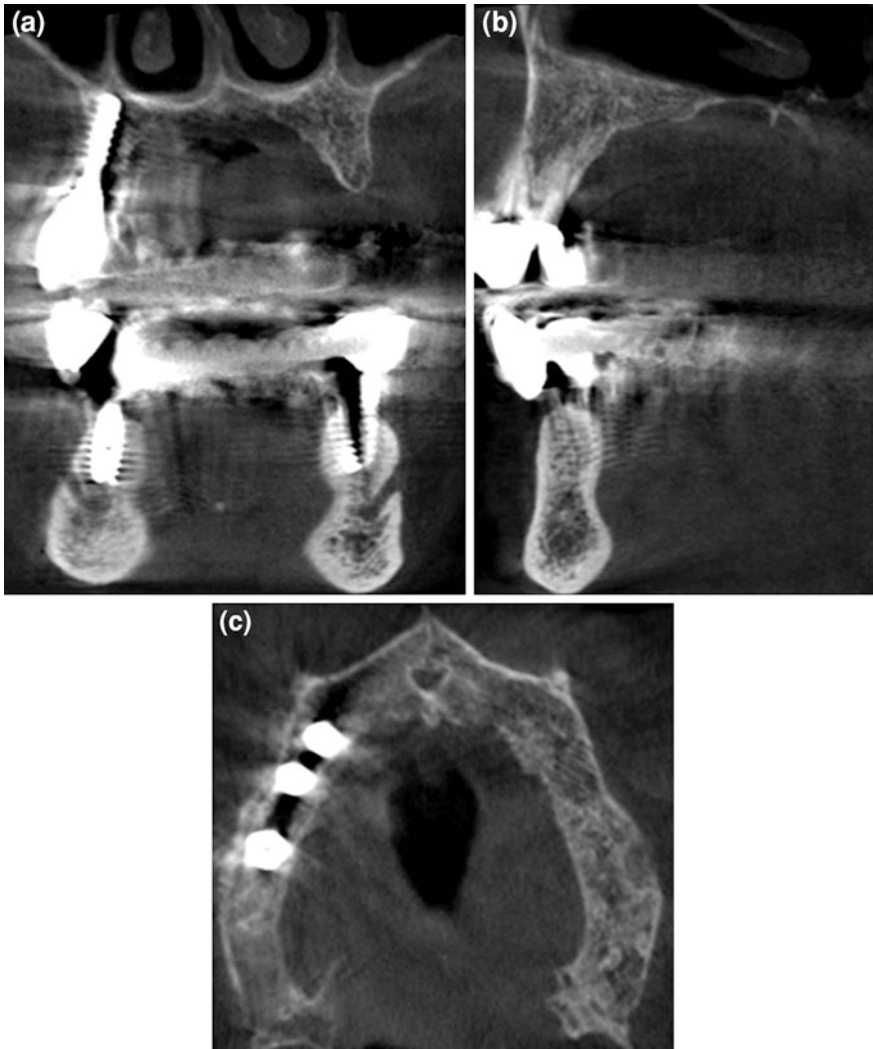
CBCT coronal (a), sagittal (b) and axial (c) scans demonstrating the edentulous left maxillary region
